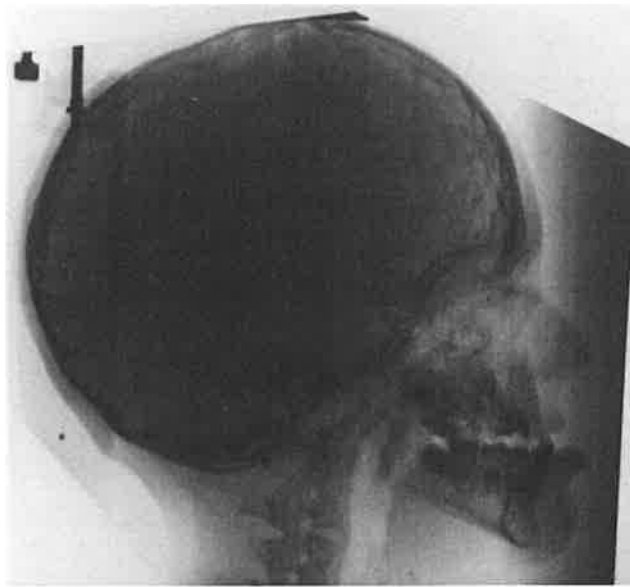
Lateral radiograph in a patient with Crouzon syndrome showing fusion of C2-3 and C4-5 vertebral bodies.
